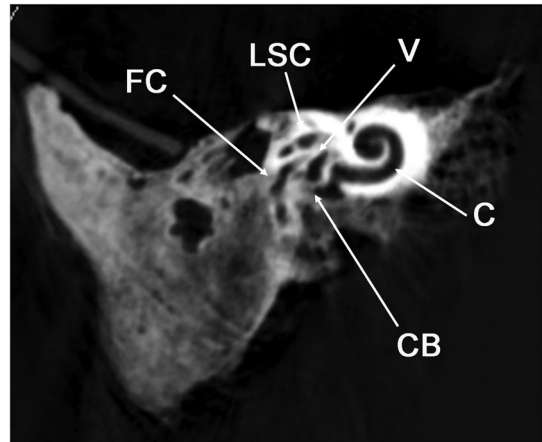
Coronal computed tomography (CT) of left temporal bone. The normal structures of the inner ear are observed. C, cochlea; CB, cochlea base; FC, facial canal; LSC, lateral semicircular canal; V, vestibule
